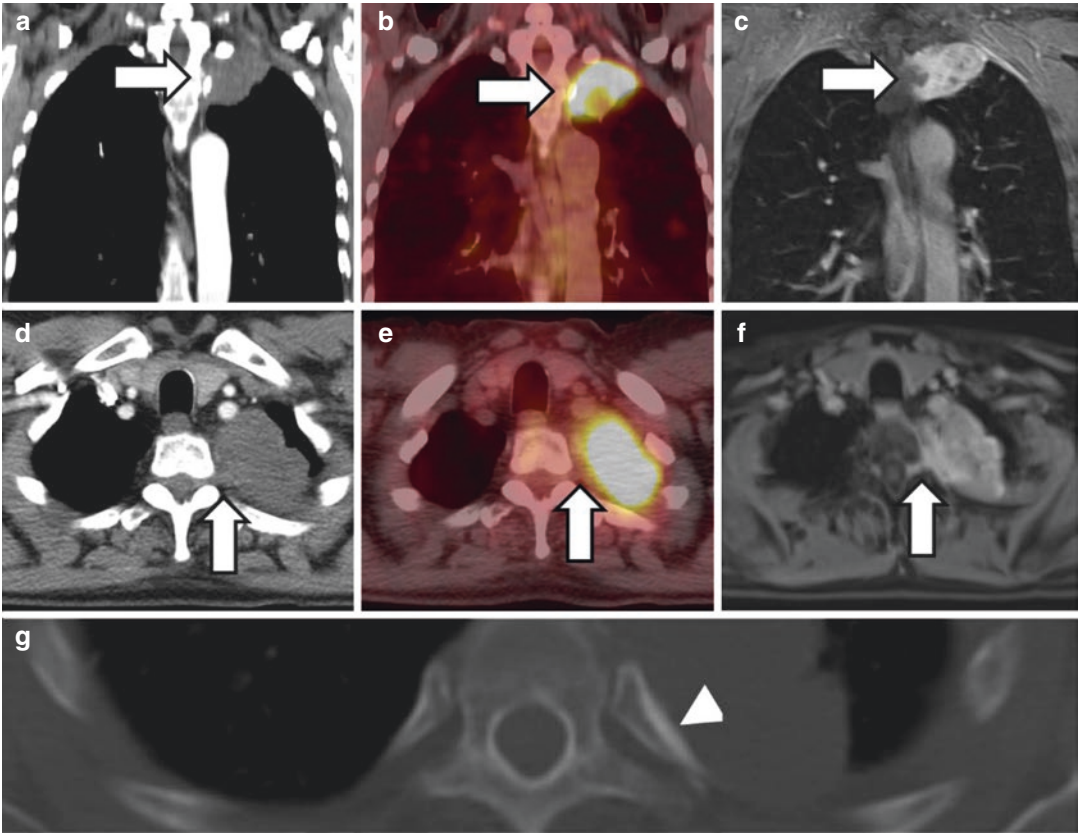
NSCLC of the left upper lobe apicoposterior segment with infiltration of the paravertebral space and adjacent neuroforamina Th2 and Th3. Evidently, the process of tumor invasion (*arrows*) is much better visualized with MRI (fat-suppressed T1-weighted gradient echo
